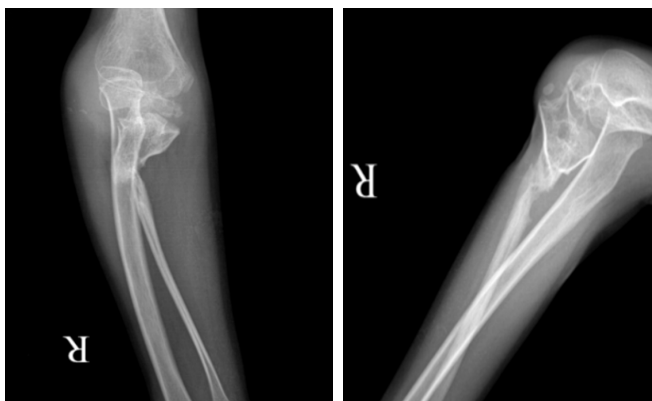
Radiographs showing post septic sequele of ulna.
